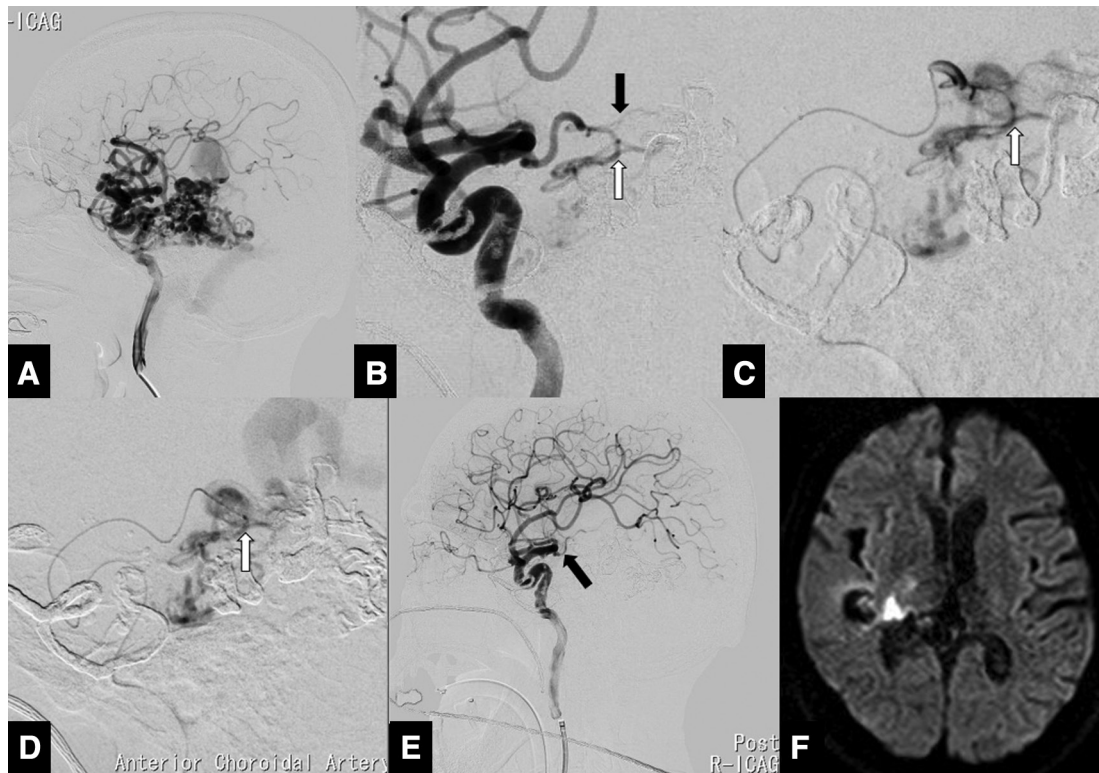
(A and B) Lateral views on right internal carotid angiography before embolization. Capsulothalamic artery (black arrow). Plexal point (white arrow). (C and D) Microcatheter angiography before embolization (right AChA). A microcatheter was unable to be guided beyond the plexal point (microcatheter tip was positioned at the plexal point). A nidus was visualized through the right AChA. Plexal point (white arrow). (E) Lateral views on right internal carotid angiography after embolization. The nidus was not visualized through the right AChA. AChA (black arrow). (F) MRI after embolization. An infarction was detected in the right lateral geniculate nucleus. AChA: Anterior choroidal artery
